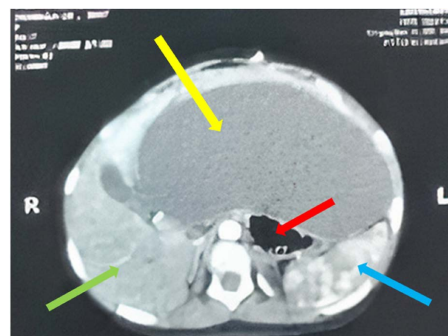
Abdominal CT, cross-section. The abdominal CSF pseudocyst appears as a low-density well-delimited abdominal mass (yellow arrow) in the peritoneal cavity, exerting mass-effect on intraperitoneal organs: tight stomach (red arrow), posteriorly displaced spleen (blue arrow) and, more rightly displaced liver (green arrow).
